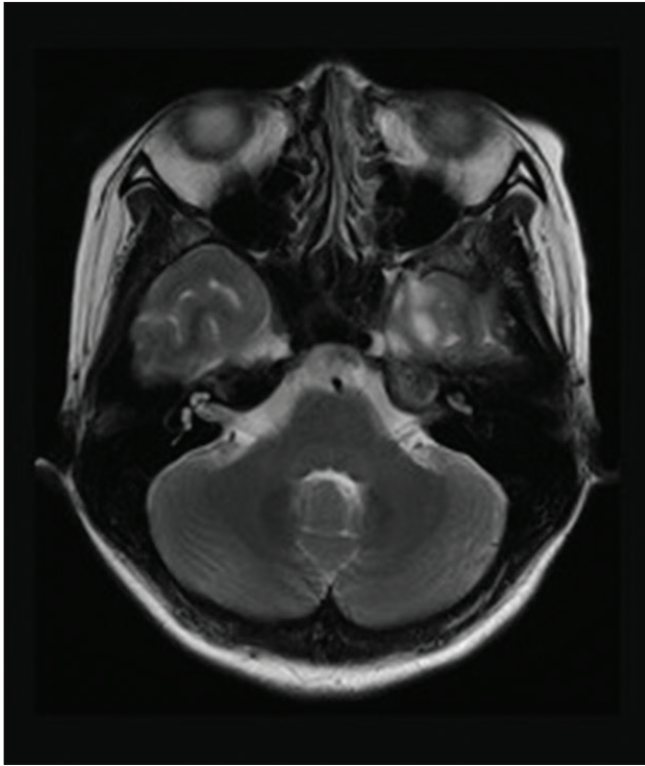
Postoperative magnetic resonance imaging (MRI). Axial T2-weighted MRI showed disappearance of cerebrospinal fluid leakage.
